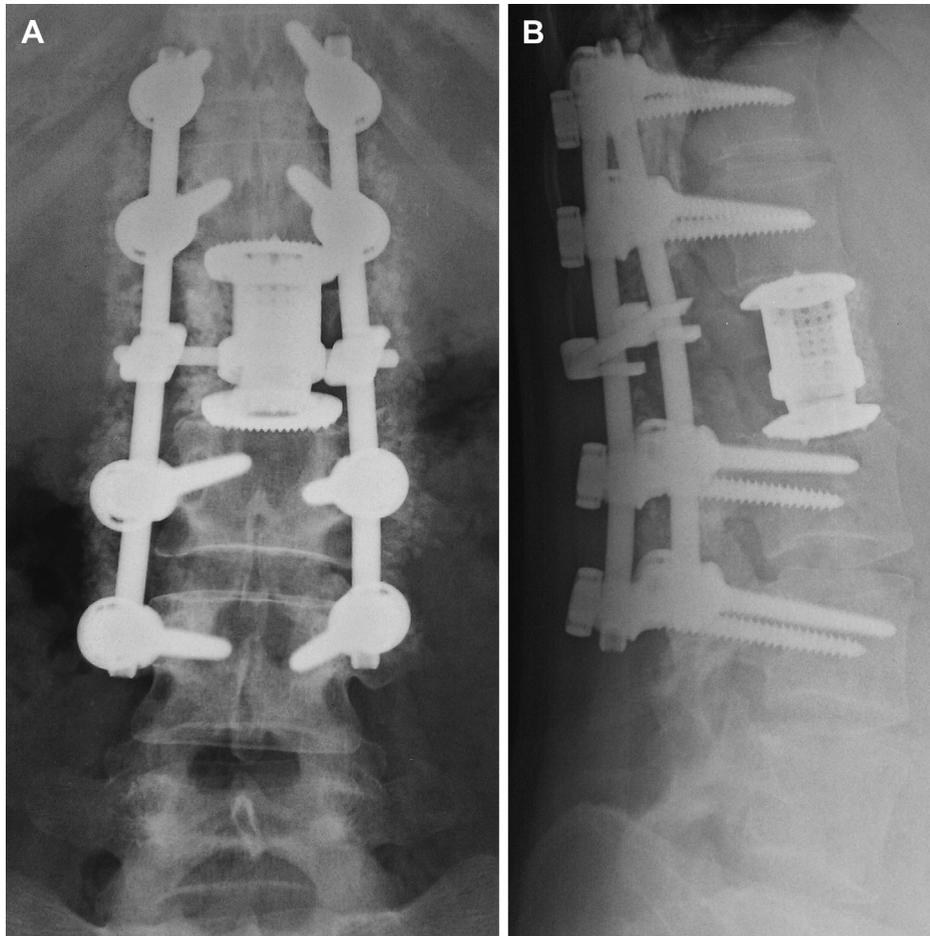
X-rays of the lumbar spine at 2 years postsurgery: (A) anteroposterior and (B) lateral films.
